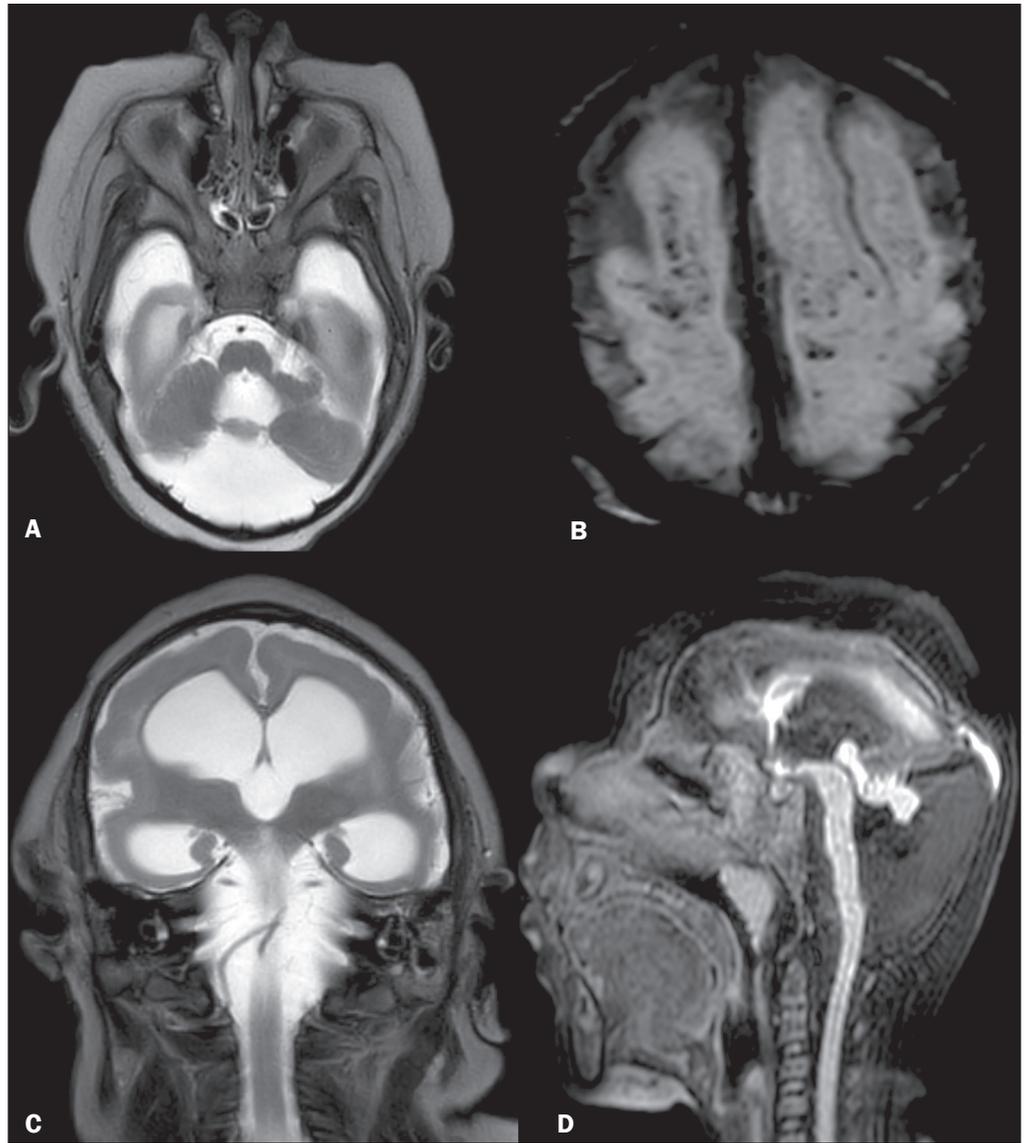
Severe brain injury on MRI scans of different patients. Axial and coronal T2-weighted MRI sequences (A and C, respectively) showing severe global volume loss with cerebellar hypoplasia (A) and ex vacuo enlargement of the lateral ventricles and subarachnoid spaces with pachygyria (C) in a 24-month-old infant. Multifocal punctate calcifications are seen along the gray-white matter junction on SWI sequence (B) in a 13-month-old infant. Sagittal T1-weighted volumetric sequence (D) showing microcephaly, hypogenesis of the corpus callosum, tectal dysplasia, brainstem hypoplasia, cerebellar hypoplasia, and mega cisterna magna in a 9-month-old infant.
